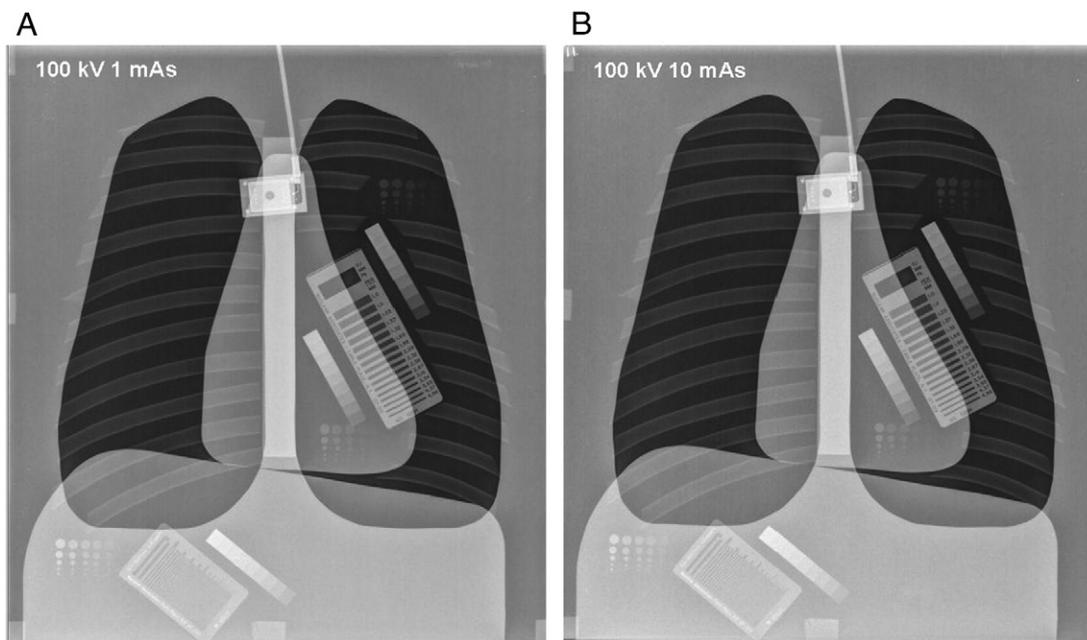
Chest radiographic images were acquired using Philips CR system with 100 kVp and 1.0 and 10.0 mA (A, B). Dose reduction was significant when the lower mAs were used compared to higher mAs, but with no significant effect on the image visualization.
